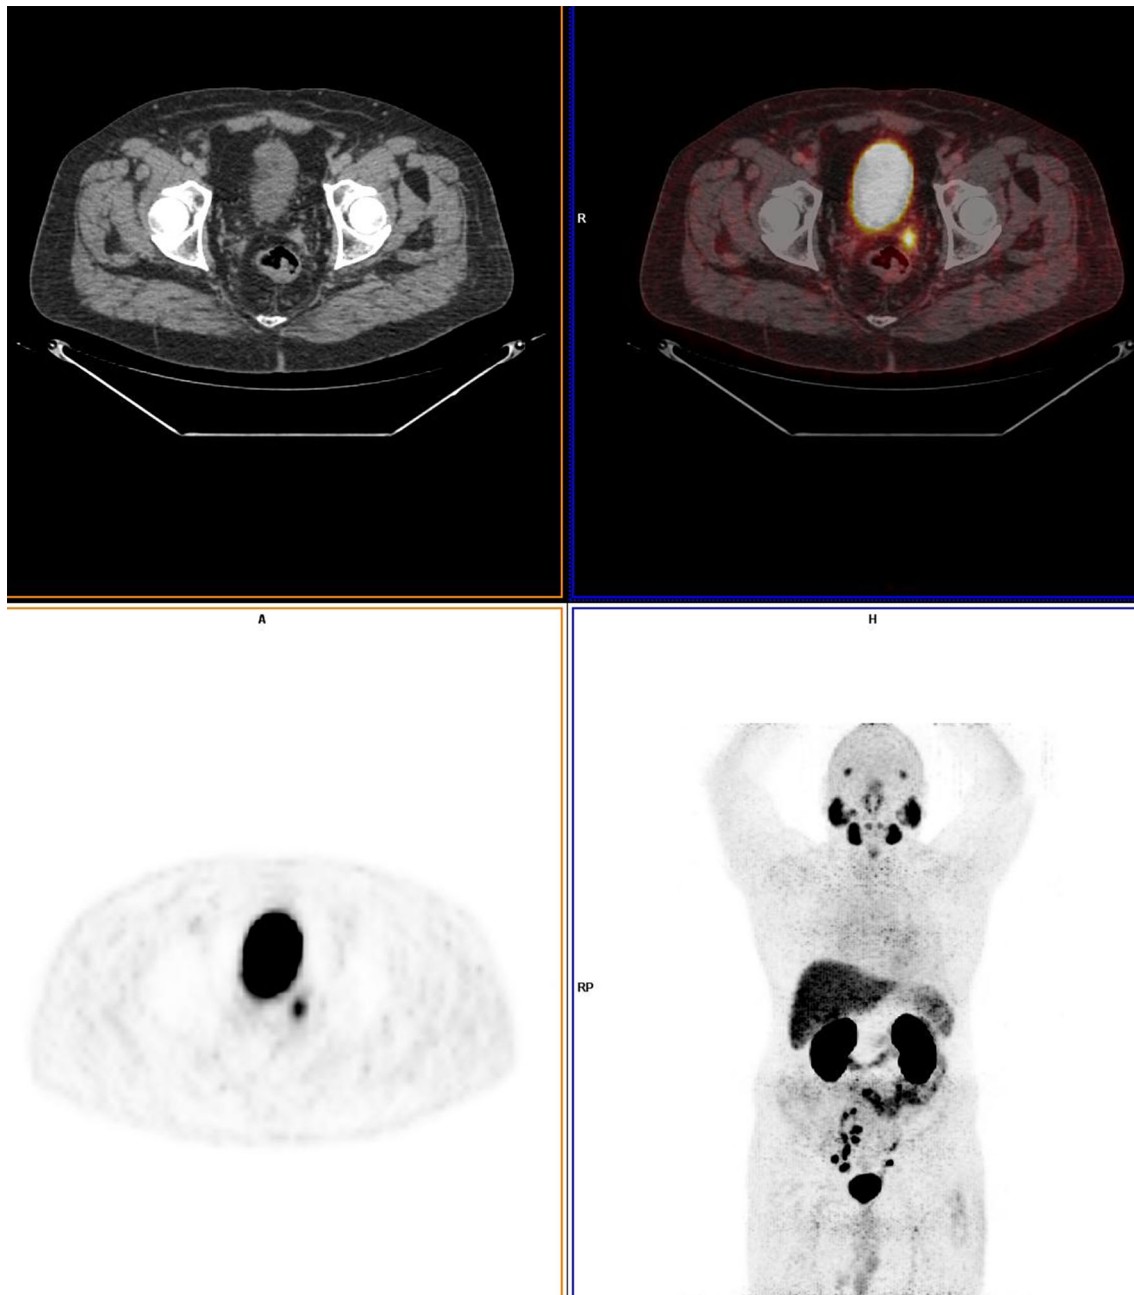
Set of images of a 68-year-old patient with status after radical prostatectomy and PSA value of 36.0 ng/mL. Tissue formation identified in the paramedian position on the left of the seminal vesicles, measuring 1.5 cm, showing radiopharmaceutical uptake (SUVmax = 11.5)
